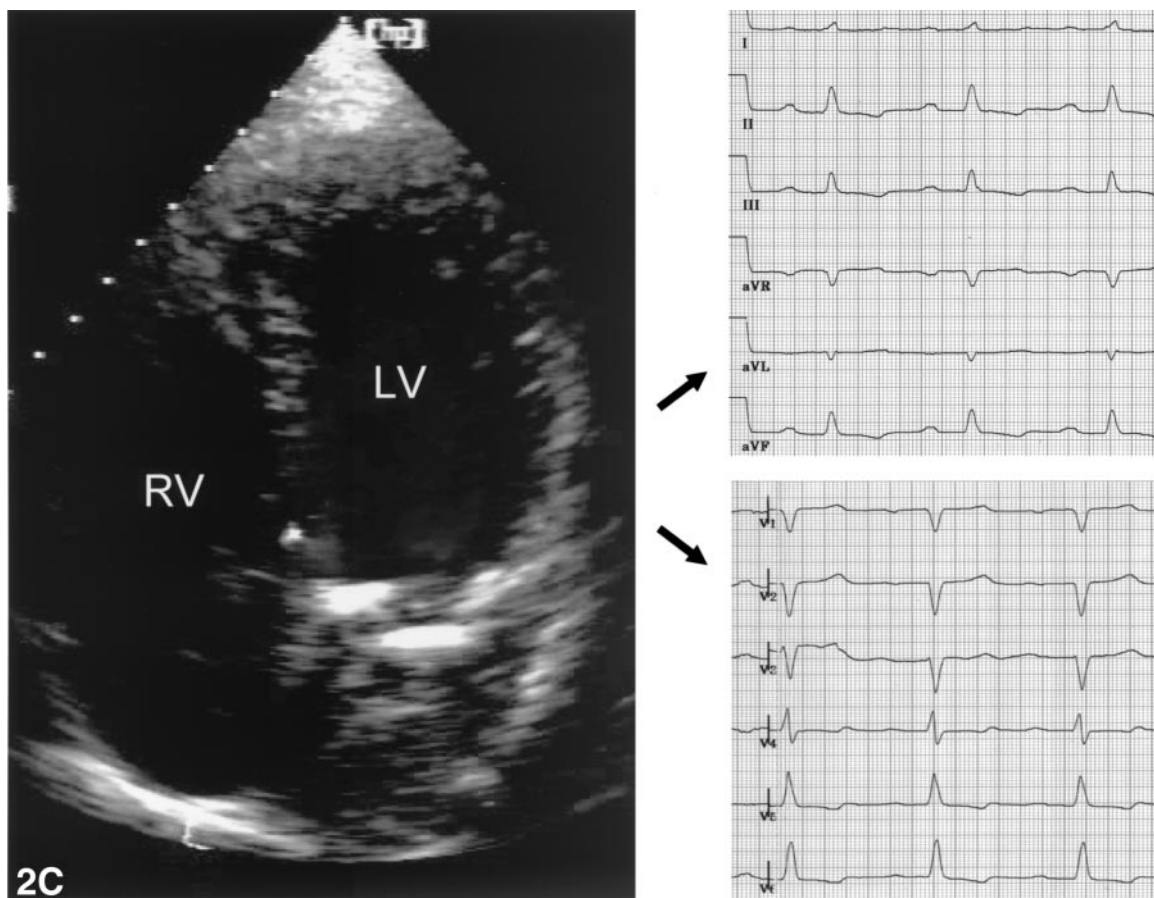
Continued from previous page. (C) Same patient six days after pericardiocentesis. The echocardiogram shows no evidence of recurrent effusion. QRS amplitude in the limb leads significantly increased. LV = left ventricle; RV = right ventricle.
